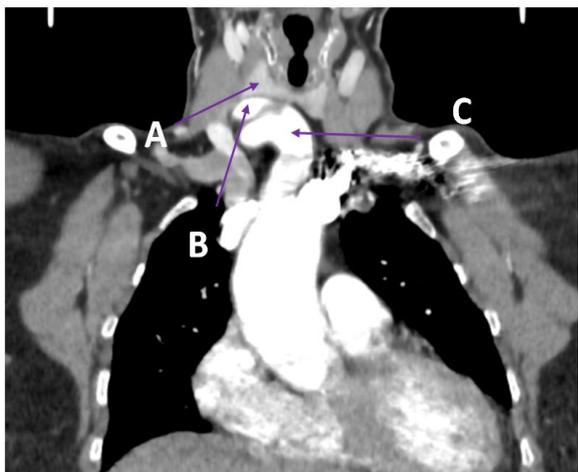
Coronal CT-angiography of aorta and supra-aortic vessels, (A) Thyroid (B) Common carotid artery (C) brachiocephalic artery
